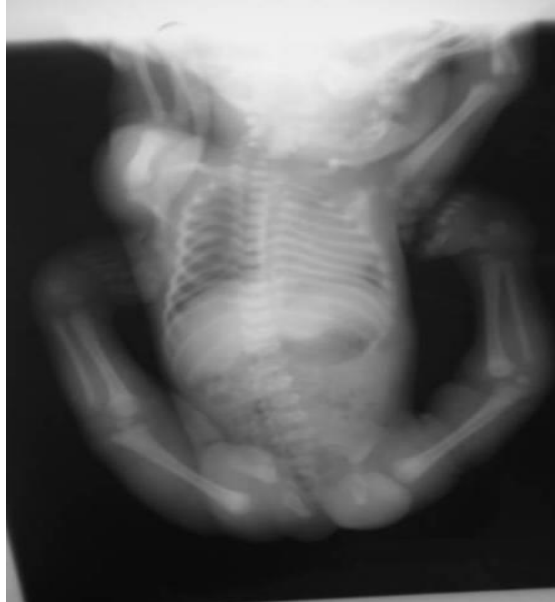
Entire skeleton radiograph of a one-month-old-girl with Larsen syndrome showed the misleading phenotype of arthrogryposis multiplex congenita
